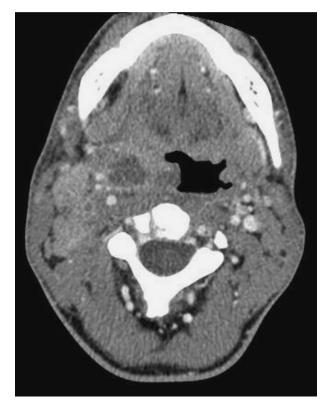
Axial computed tomography scan showing a right parapharyngeal abscess associated with a right internal jugular vein thrombosis (Lemierre's syndrome).
